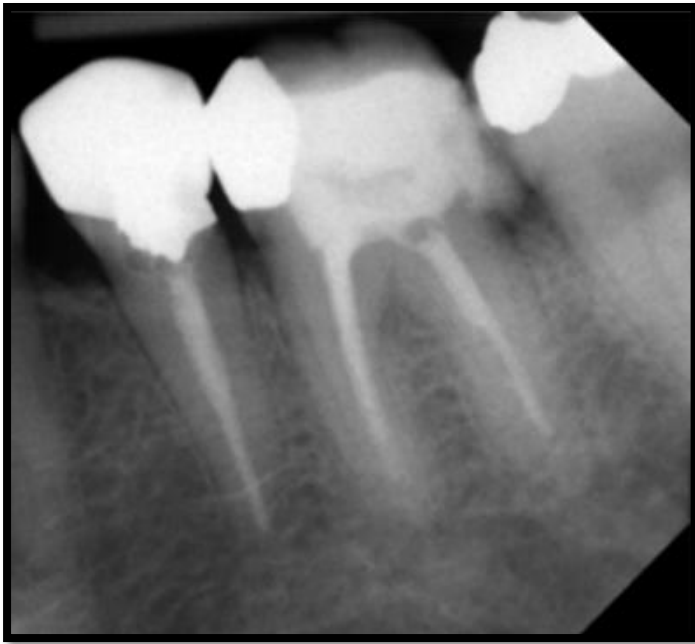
#36 Root Filling Terminating >2 mm from the Radiographic Apex
